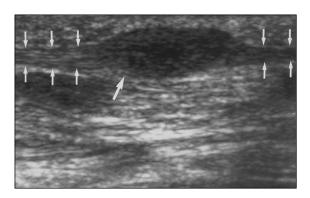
Longitudinal sonogram of midfoot of 32-year-old woman shows well-defined fusiform hypoechoic nodule (*large arrow*) arising within plantar fascia (*small arrows*). Lesion shows moderate acoustic enhancement.
